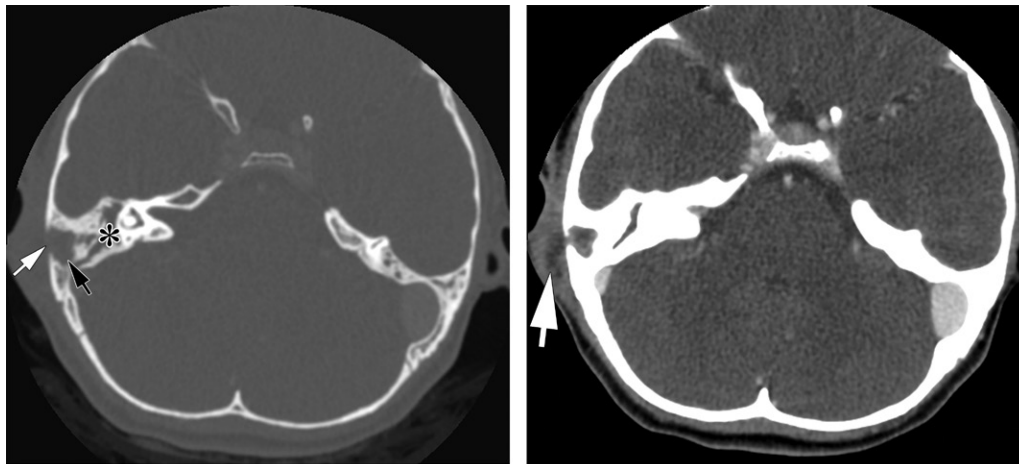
Right coalescent mastoiditis with extracranial abscess in a 13-year-old girl. (a) Axial contrast-enhanced CT image (bone window) shows tympanomastoid opacification (*). There is coalescence of the right mastoid air cells (black arrow) with breakthrough of the overlying cortex (white arrow). (b) Image in a obtained in soft-tissue windows shows an overlying or developing abscess (arrow).
